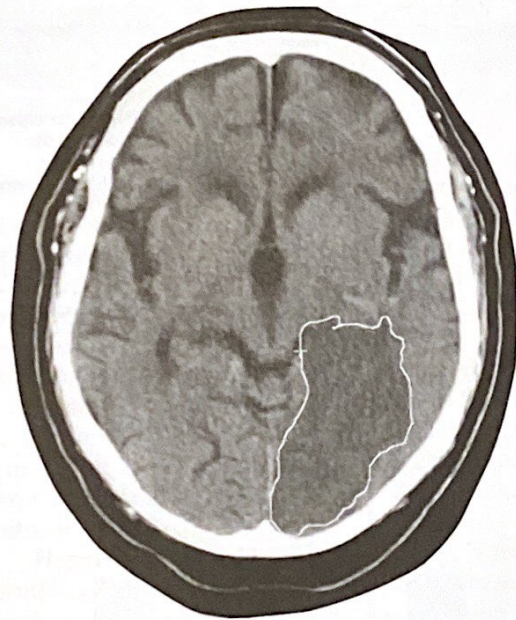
On this magnetic resonance image of a brain, the area of a bleed is visible in the lower right.
